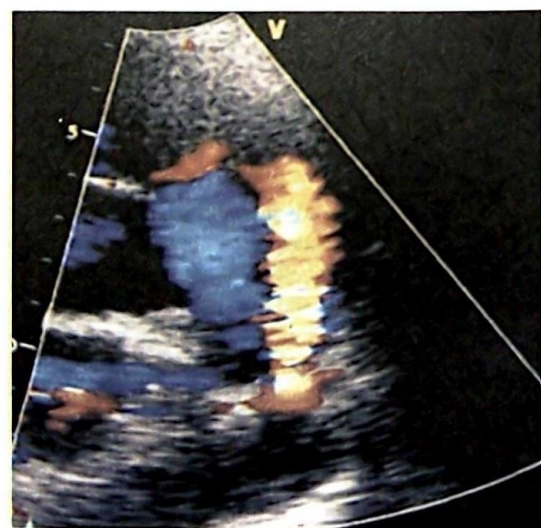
Parasternal short axis echocardiographic view of the aortic valve showing the right ventricular outflow tract and the pulmonary main artery (PA). Colour flow imaging of systolic left-to-right shunt (red) through the patent ductus arteriosus (PDA)
